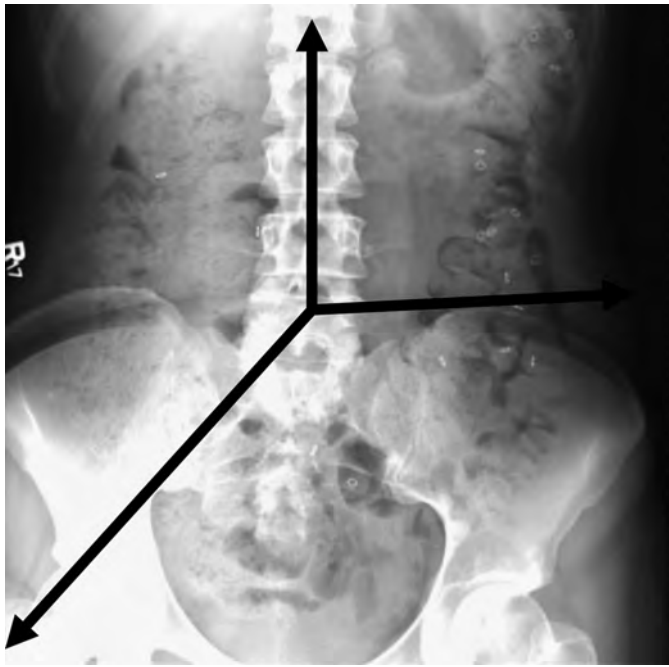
Colon transit study. Plain film demonstrates radiopaque markers. For the purpose of counting, the colon is divided into three segments—left colon, right colon, and rectosigmoid.
